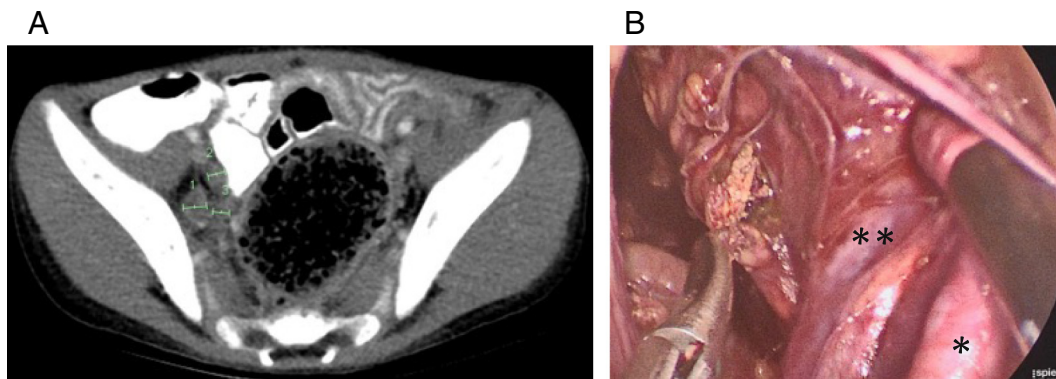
Adequate visualization of retroperitoneal distal pelvic vessels in a patient with pelvic adenopathy. (A) Computed tomography showing right pelvic adenopathy coursing along the right pelvic sidewall. (B) Distal external iliac artery (*) and vein () retracted laterally to expose necrotic pelvic adenopathy.
